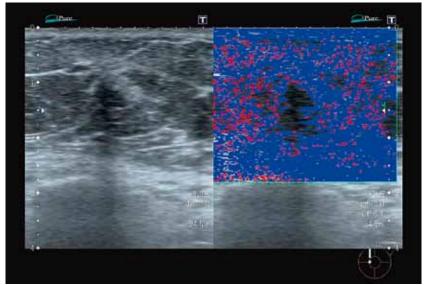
The lesion is suspicious in the B-mode scan and realtime tissue Doppler image obtained without tissue compression.
